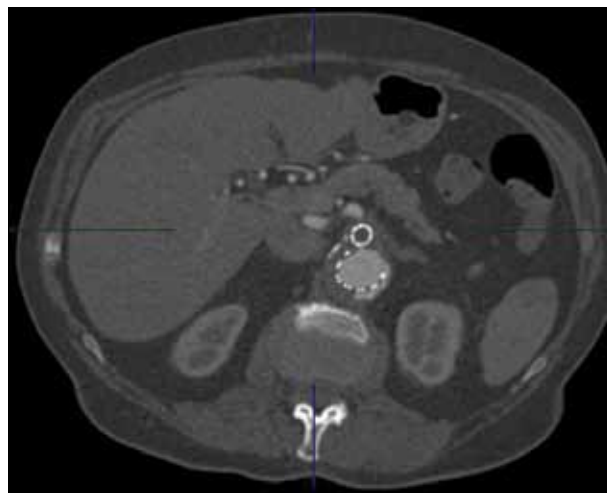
CT scan with contrast in the aneurysm sac.
